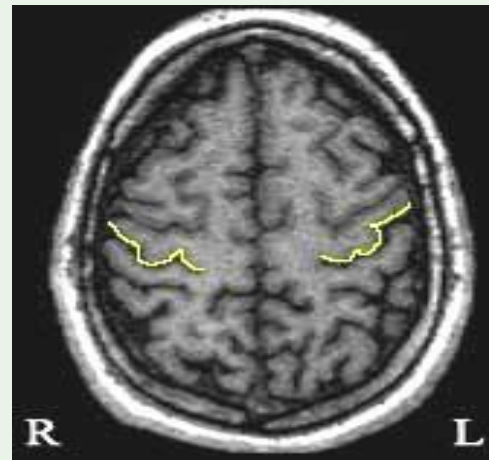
(b): Anatomical Measure of the Motor Knob: The motor knob is outlined on the axial volumetric MRI image with the "omega" configuration shown in the left hemisphere, and the inverted "epsilon" configuration shown in the right hemisphere.
